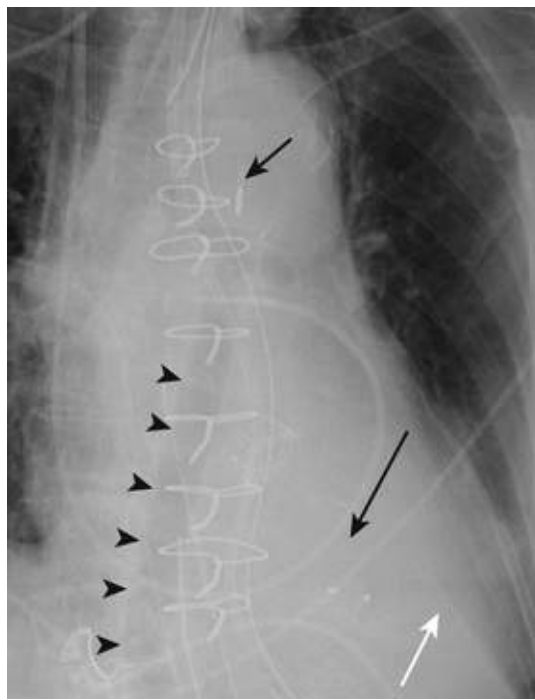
Assessment of cardiac and intravascular devices. Coned-down view of portable chest radiograph of patient in intensive care unit shows an intra-aortic balloon device (IABP), with its metallic marker (*short black arrow*) projecting a few centimeters below the aortic arch, indicating that it is well positioned. The inflated balloon of the IABP creates a radiolucent column (*arrowheads*) over the descending aorta. A ventricular septal occluder device (*long arrow*) projects over the heart. The positions of other tubes and catheters are also depicted, such as the pulmonary arterial catheter with its tip in the right pulmonary artery. The left ventricle apex is obscured by a small, left pleural effusion (*white arrow*).
